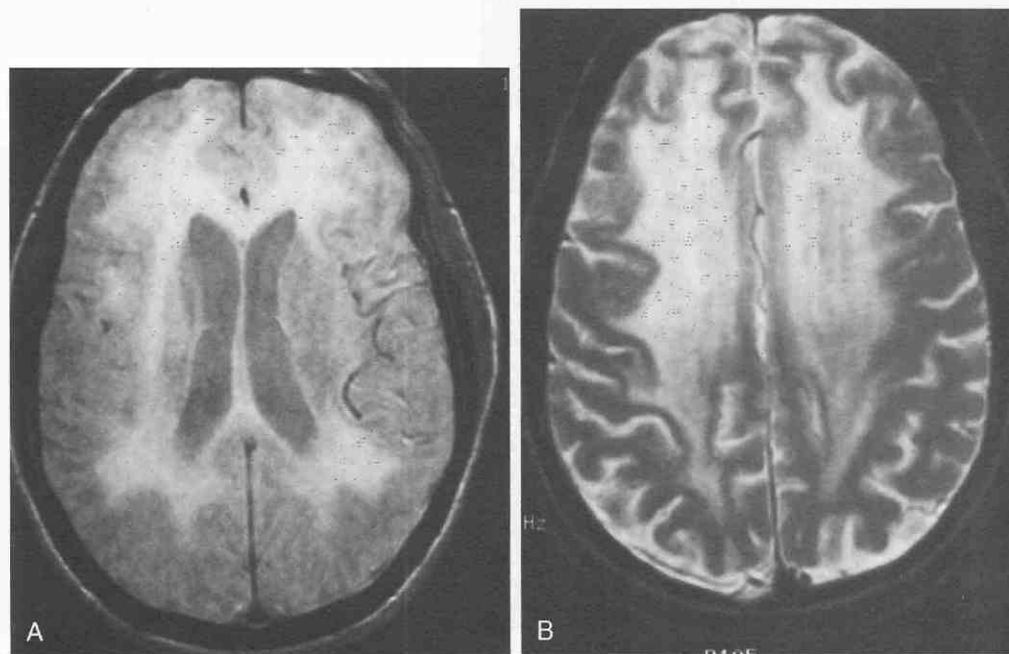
Human immunodeficiency virus encephalitis in a 39-year-old patient with acquired immunodeficiency syndrome (AIDS) and rapidly worsening dementia. A and B, Proton-density and T2-weighted axial MR images show widespread diffuse hyperintensity of the deep cerebral white matter. Not shown is similar involvement of the pons and mesencephalon.
